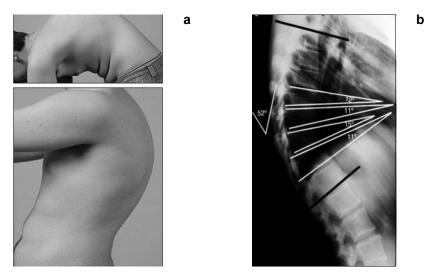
Round kyphosis of a Scheuermann's disease patient (a). X-ray picture of a Scheuermann's disease spine (b) [17].
